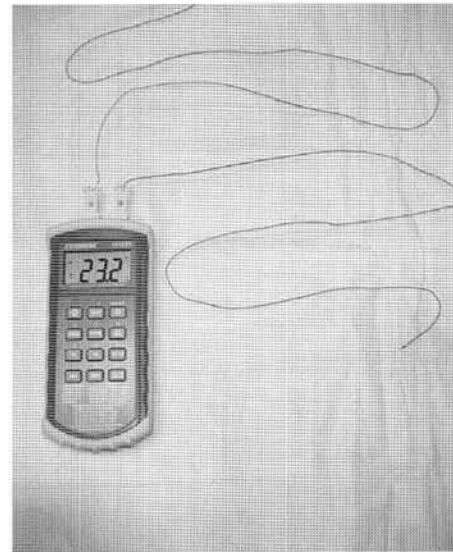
HH508 Digital Thermometer® (Omega®, Samford, CT) was utilized to measure the surface skin temperature.
